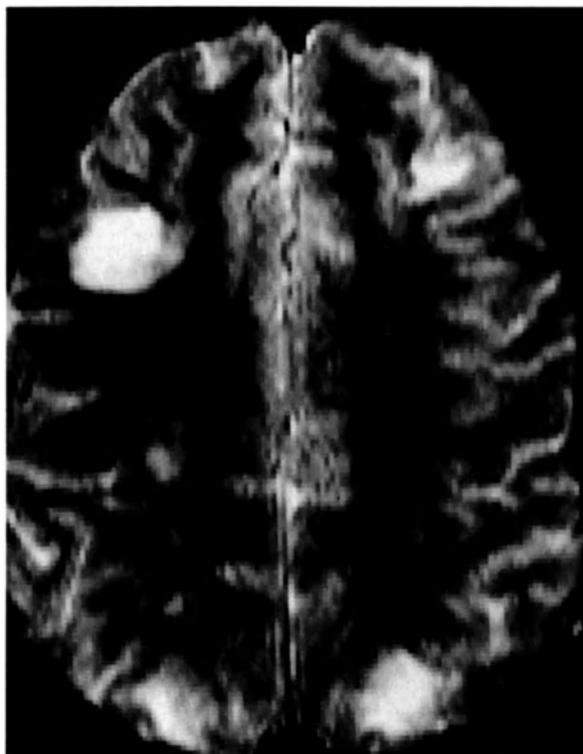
Areas of cryptococcal cerebritis shown as high signal by MRI (T<sub>2</sub>-weighted). These were not identified on a CT scan taken at the same time.
